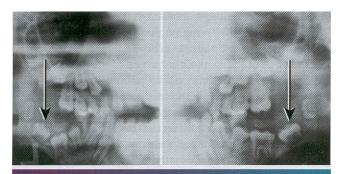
• Mucopol ysaccharidosis. Radiographic examination of the dentition of a child affected by Hunter syndrome typically shows radiolucencies (arrows) associated with the crowns of unerupted teeth.
